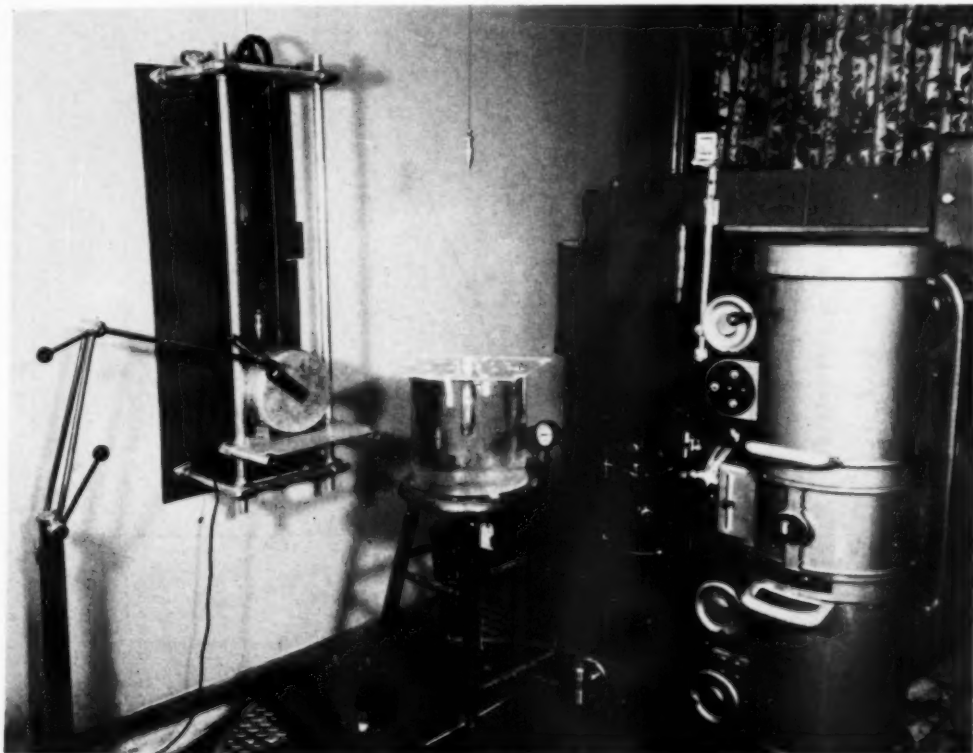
Arrangement of rotation chair, x-ray tube, and transit chamber.
